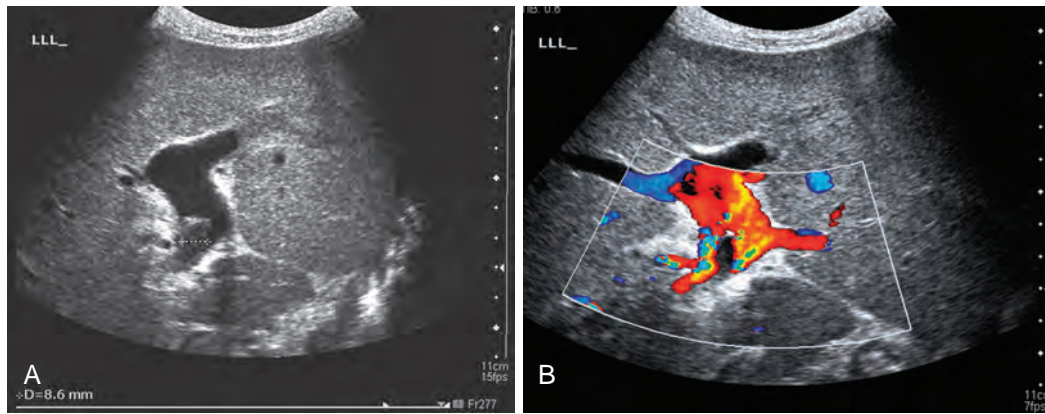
Nonocclusive thrombus in the right portal vein. Nonocclusive thrombus in the right portal vein (calipers in A) seen on gray-scale (A) and color Doppler (B) images.
